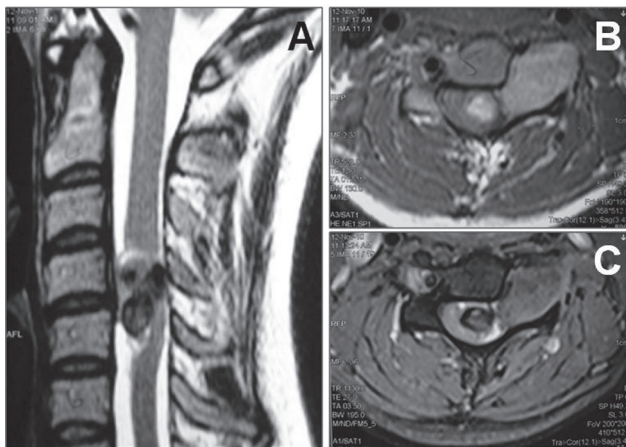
A: MRI study with sagittal T₂-weighted sequence disclosing a hypointense heterogeneous intradural C4–C5 mass, disrupting the medulla. B: axial T₂ proton density (PD)-weighted sequence showing a slightly hyperintense. C: Axial FLAIR isointense extramedullary neoplasm extension for the left C5 root without bone destruction, presenting an hourglass shape directed toward the paravertebral area. FLAIR: fluid attenuated inversion recovery, MRI: magnetic resonance imaging.
